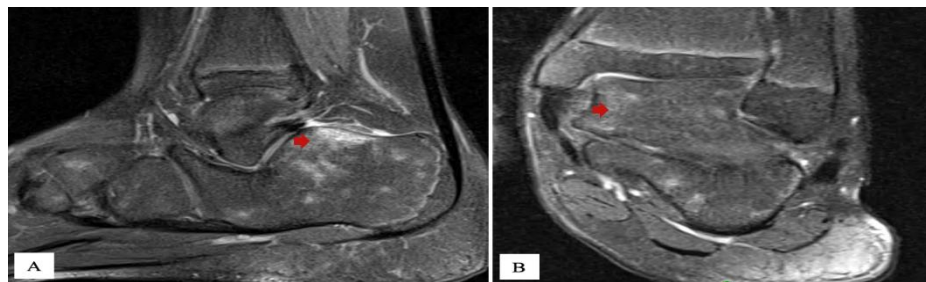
MRI right ankle, images A, B: A - PDFS sagittal image showing hyperintense ELMSI in the subcortical region of the calcaneum, talus, navicular, and cuboid bones (red arrow). B - PDFS coronal image depicting hyperintense ELMSI in the subcortical region of the calcaneum, talus, navicular, and cuboid bones (red arrow).
